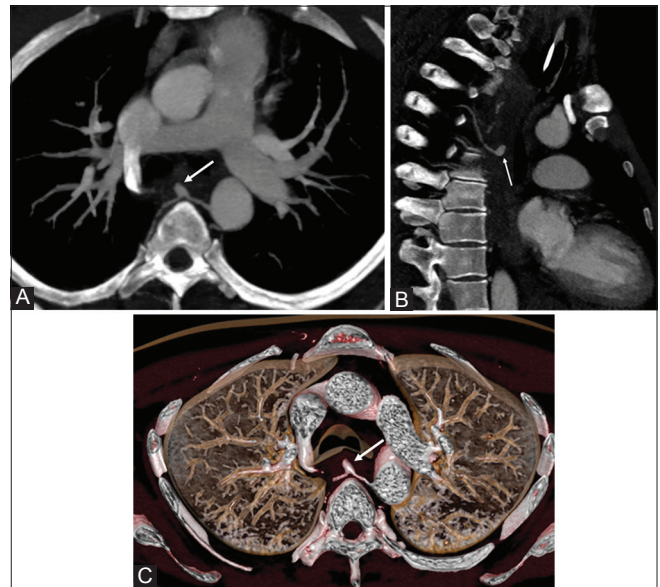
Reconstructed CT angiogram maximum intensity projection image showing the right 3rd intercostal artery pseudoaneurysm (arrow) (A) axial (B) swirled lateral (C) 3D reconstructed
